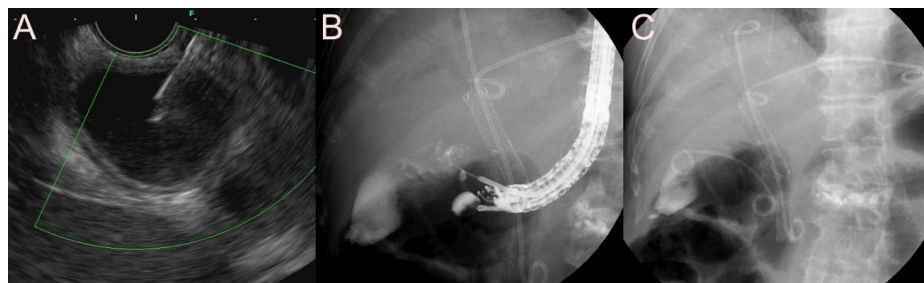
Endoscopic ultrasound-guided gallbladder (GB) drainage using the 7-Fr double-pigtail plastic stent (DPPS) for obstructive cholecystitis after biliary stent placement. (A) Endosonographic images showing a markedly dilated GB with large amounts of sludge and heterogeneous debris. (B) Fluoroscopic images showing a 19-gauge needle puncture into the GB neck portion. (C) Fluoroscopic images showing the 7-Fr DPPS placed between the duodenum and GB.
